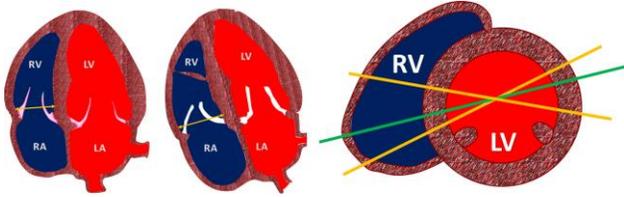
Apical 4C view on left and RV Focused Apical 4C chamber view (centre) making the basal diameter to be seen in its full extent (see the green line on right).
